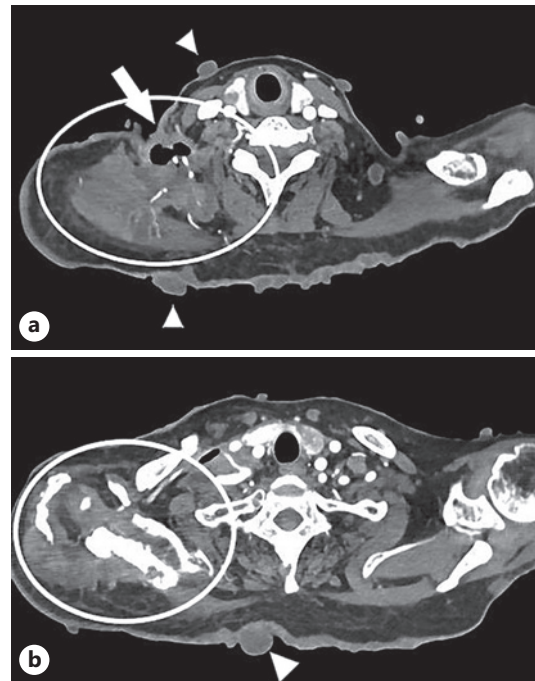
Enhanced CT images before radiotherapy. a Soft tissue mass is observed in right clavicular fossa (circle), and skin ulcer is also observed (arrow). Neurofibromas are seen on the skin (arrowhead). b Slice is obtained slightly caudal to A. Destruction on the right scapula and surrounding soft tissue mass is observed (circle).
